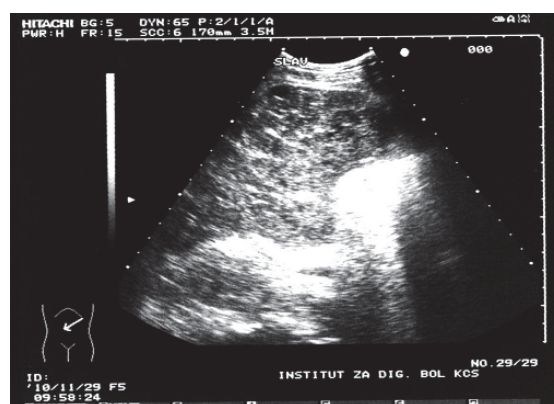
Abdominal ultrasound revealed the inhomogeneous liver with wavy edges and regular hypoechoic nodules, surrounded by a thin hyperechoic bands.
